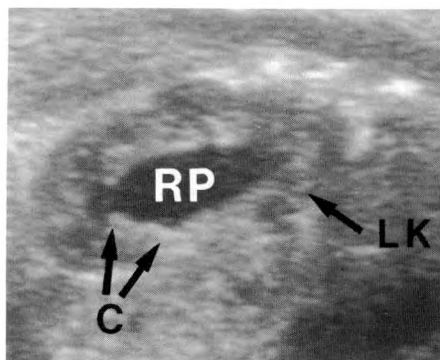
In utero sonogram of left fetal kidney (LK) shows pelvis/kidney ratio of 0.45, which is within normal range. However, dilated calices (C) are present. Such cases were considered to be hydronephrotic kidneys. RP = renal pelvis.
